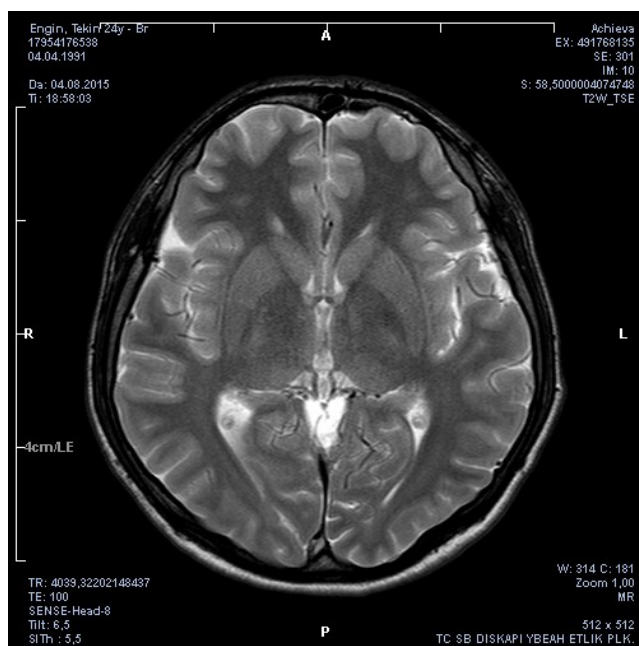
Normal T2 axial Magnetic Resonance Imaging (MRI).
